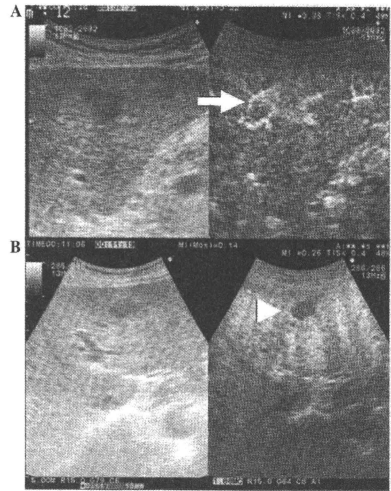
A nodule diagnosed as a typical hepatocellular carcinoma by contrast-enhanced ultrasonography. (A) The nodule was enhanced in the arterial phase (arrow) and (B) revealed as a defect in the Kupffer phase (arrowhead).
